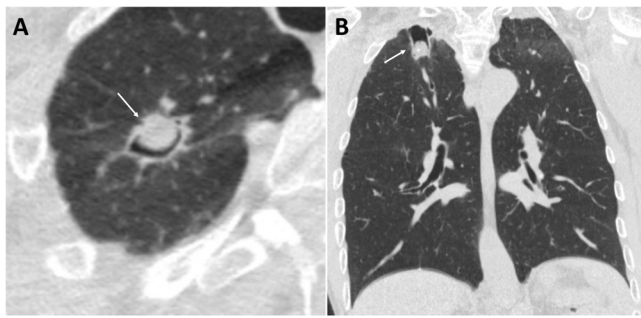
Chest computed tomography in axial (A) and coronal (B) view showing a cavitary pulmonary in the right upper lobe (arrows).
